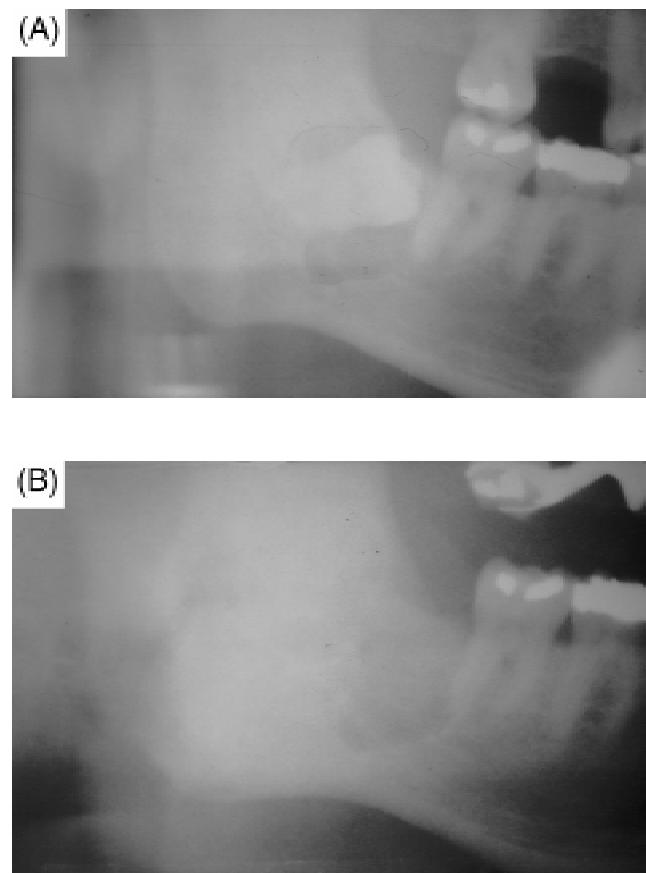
Use of bioactive glass to fill bone defects: X-rays of (A) impacted third molar prior to extraction and (B) extraction site 3 months after filling with 45S5 bioactive glass particulate. Note that new bone has filled the space with an X-ray density equivalent to normal bone. (Photo courtesy of Dr. King Smith.)
